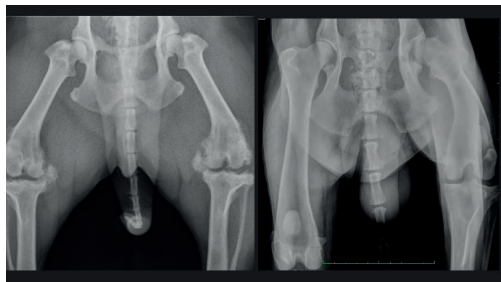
90 days follow-up radiograph imaging demonstrates notable improvements including preservation of joint space width, absence of further osteophyte development and reduction in periarticular soft tissue density, suggesting decreased inflammation and healing after one PRP administration
